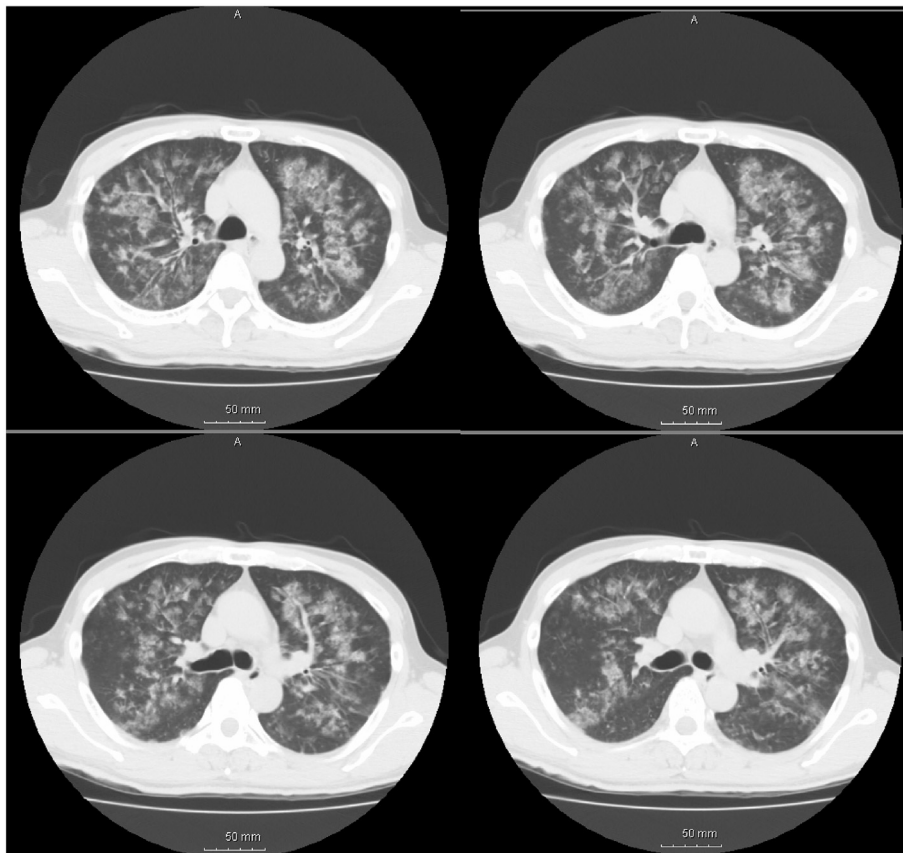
Thoracic computed tomography (CT) disclosed bilateral peribronchovascular ground glass opacity, as well as centrilobular faint nodules.
